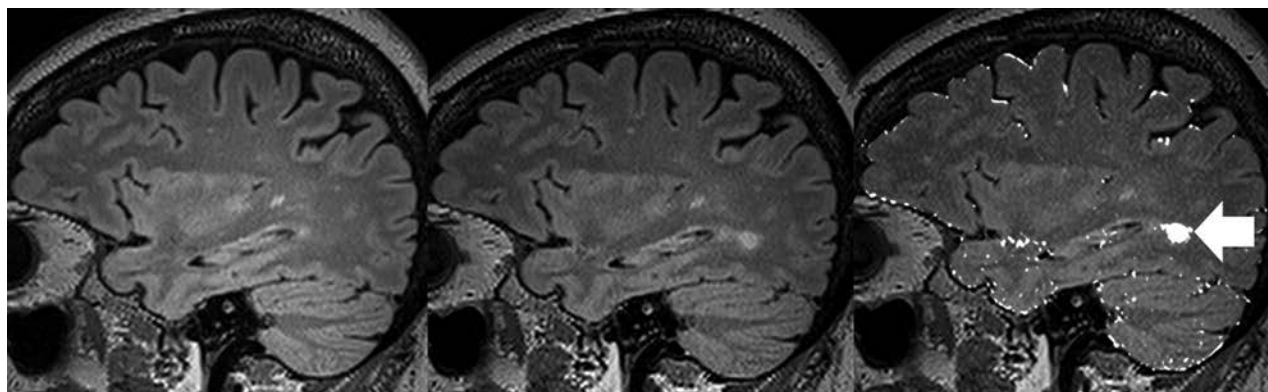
Example of VisTarsier output. From left: volumetric sagittal T2 FLAIR of previous study; volumetric sagittal T2 FLAIR of current study; and “New Lesions” map. NB: the usual output of the “New Lesions” map is colored in orange, whereas it is shown here colored *white*. The new lesion has been highlighted (*arrow*). There are slight misregistration errors at the edges of the brain, which can be dismissed as such by comparing the 2 studies on the left.
